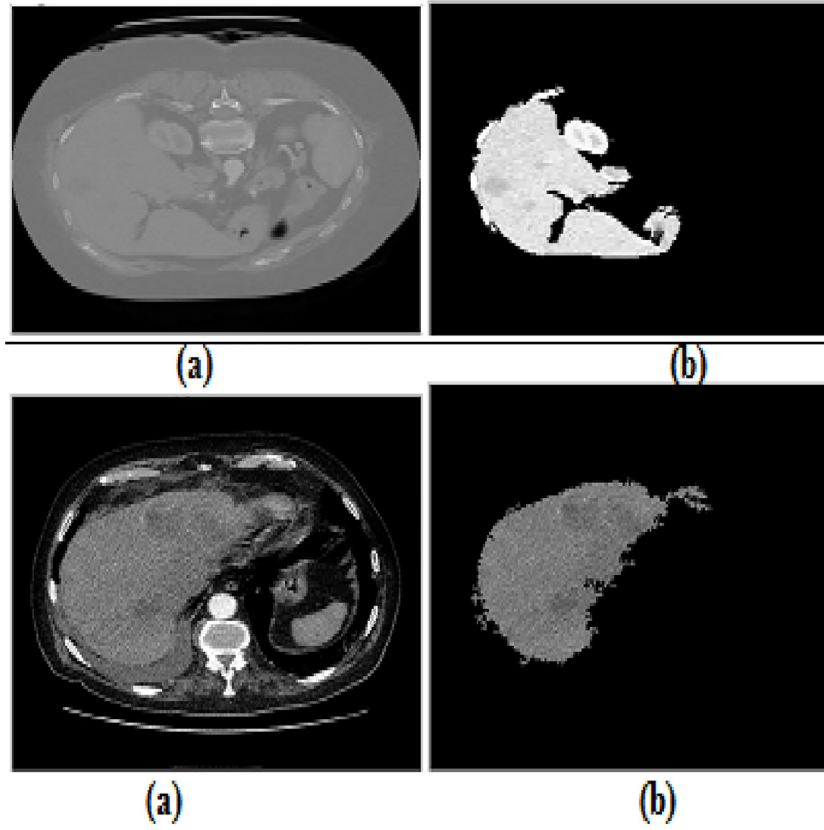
Results of different abdominal CT images to prove the proposed approach is less sensitive to noise to extract liver parenchyma. (a) Original noisy image and (b) liver segmentation.
